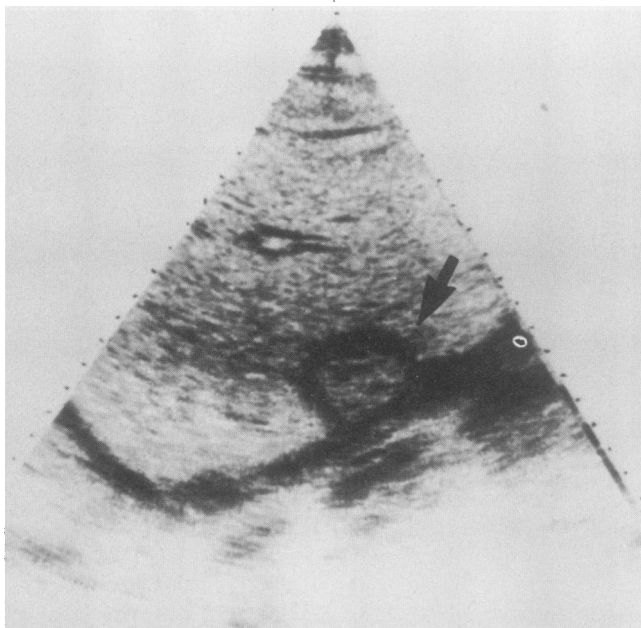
Longitudinal view of a solitary amebic abscess (arrow) on liver ultrasonography.
